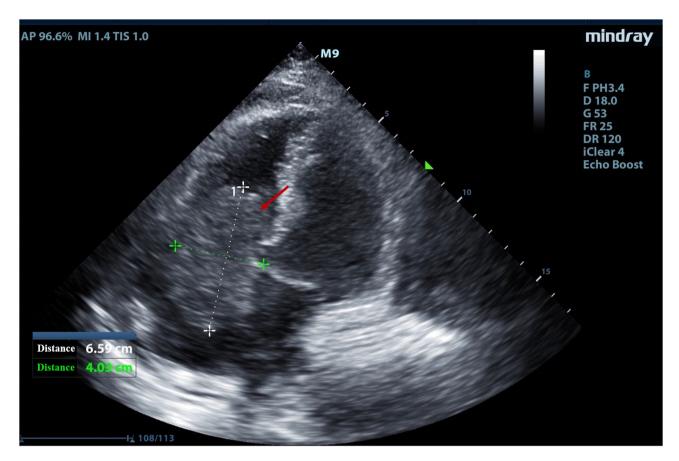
Ultrasound examination of the right heart. An ultrasound examination of the heart revealed the presence of moderate to strong echogenic masses within the right heart cavity, accompanied by an enlargement of the right atrium, as indicated by the arrow.
